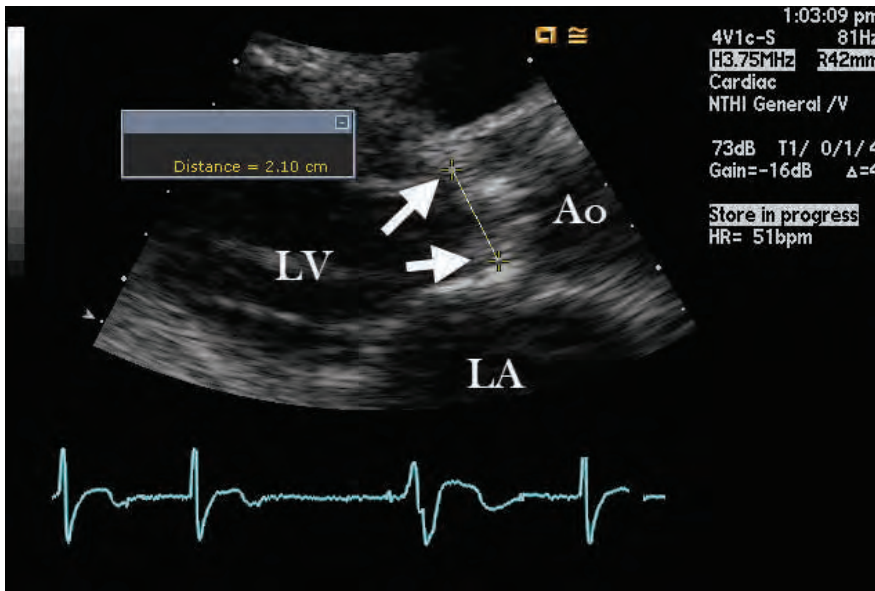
Parasternal long axis transthoracic view measuring the distance between aortic valve hinge points. Arrows indicate hinge points of aortic valve. Ao, aorta; Dist, distance between hinge points; LA, left atrium; LV, left ventricle.
